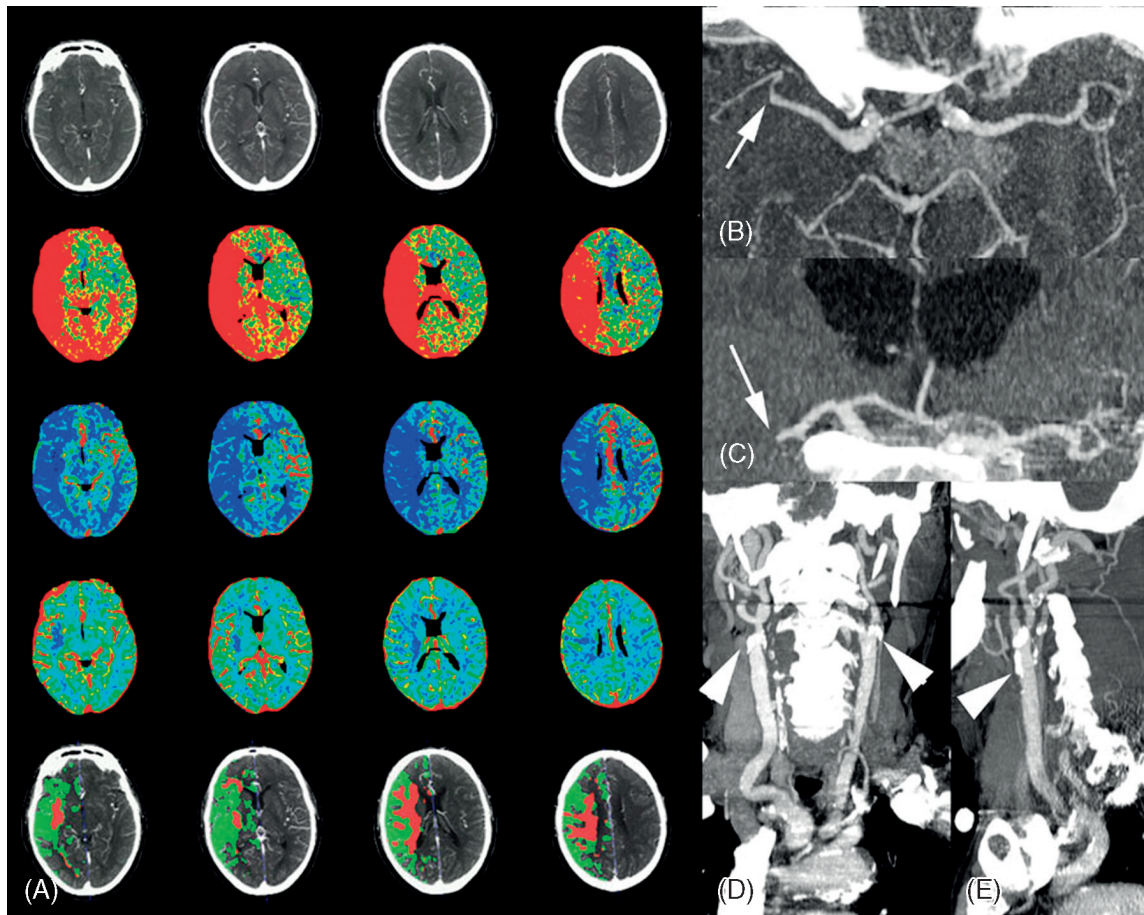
Modern CT survey in a 62-year-old male patient admitted in our emergency room with a left hemisindrome, including (A) perfusion-CT and (B–E) CT-angiography (CTA). (A) From the perfusion-CT raw data (first line), three parametric maps can be extracted, relating to mean transit time (MTT, second line), regional cerebral blood flow (rCBF, third line) and regional cerebral blood volume (rCBV, fourth line), respectively. Application of the concept of cerebral vascular autoregulation leads to a prognostic map (fifth line), describing the infarct in red and the penumbra in green, the latter being the target of thrombolytic drugs. (B,C) CTA affords identification of the origin of the hemodynamic disturbance demonstrated by perfusion-CT. In the present patient, it relates to an occlusion at the right M1–M2 junction (*arrows*). (D,E) Finally, CTA features bilateral calcified atheromatous plaques at both carotid bifurcations (*arrowheads*).
